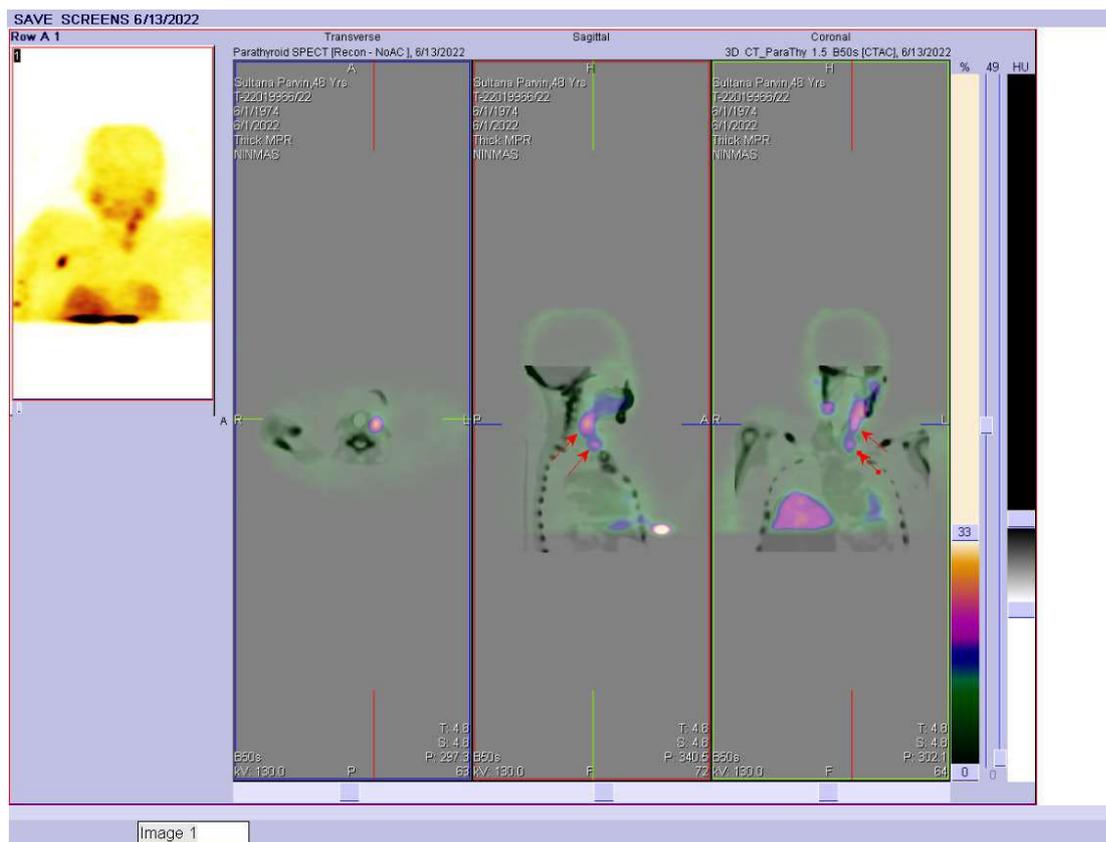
A 48years old female positive for parathyroid Adenoma in Hybrid SPECT/CT Tc-99m Sestamibi Scan
